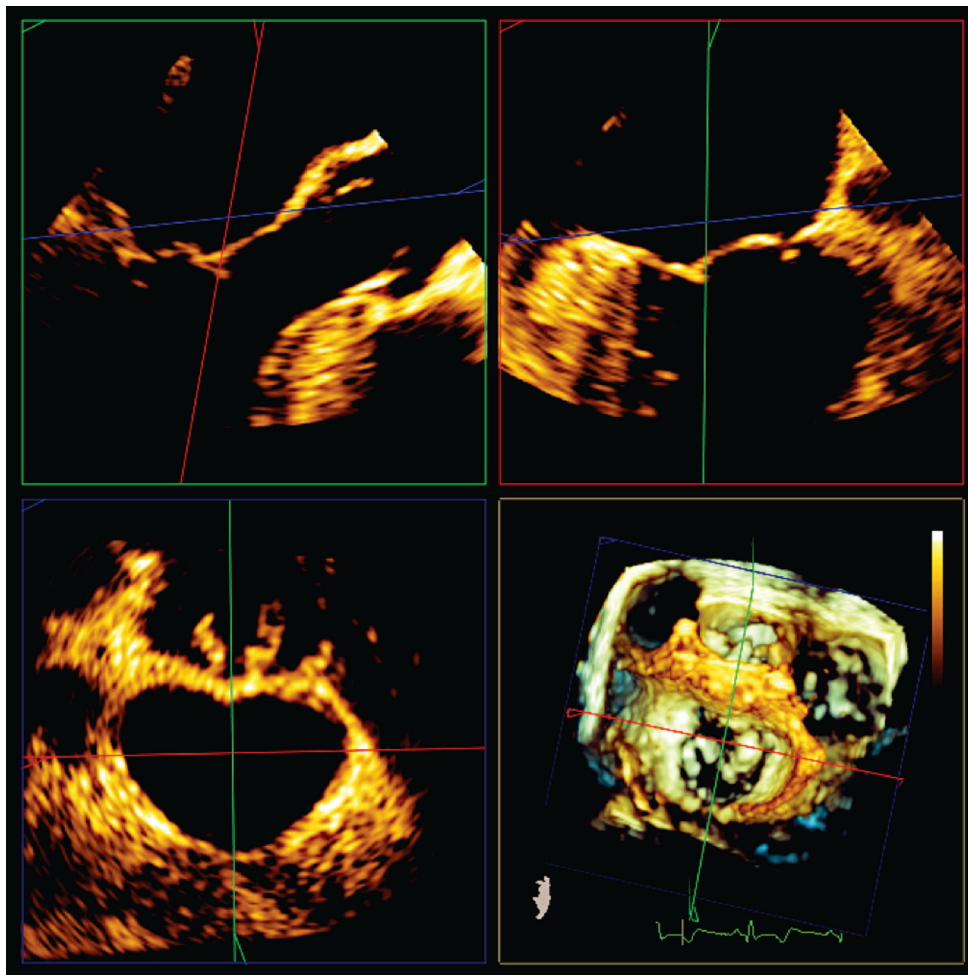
■ Multiplanar reformatting (MPR) of three-dimensional echocardiographic images can allow for more precise measurements by aligning orthogonal planes across structures of interest. In this case the planes are aligned so that the area and diameters of the mitral annulus (*bottom left*) can be measured.
